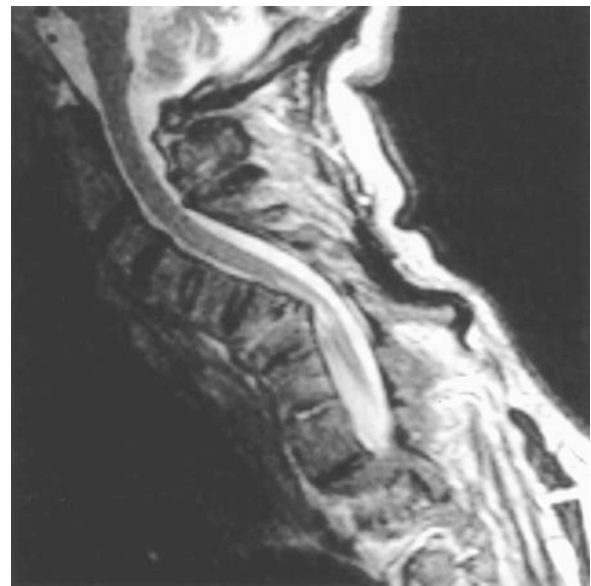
Sagittal T2-weighted MR image of the cervical spine performed 8 months later shows progressive cervical kyphosis of the C6-C7 level and myelomalacia
